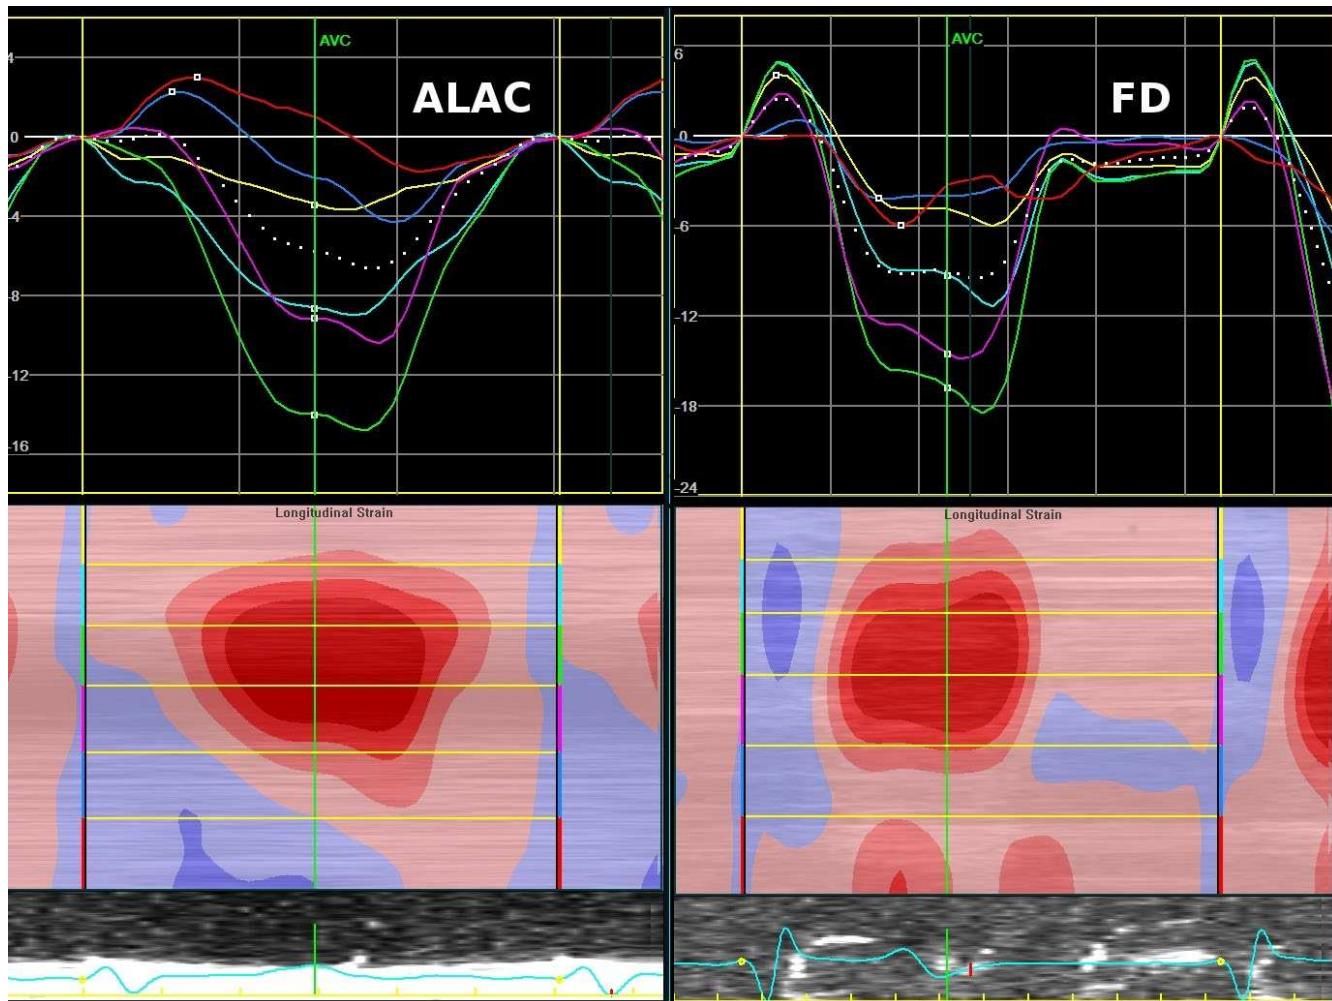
Examples of visually similar patterns of relative apical sparing of longitudinal strain in the A4C view in a patient with ALAC and FD, respectively (A4C = apical 4-chamber view; ALAC = AL amyloid cardiomyopathy; FD = Fabry disease-related cardiomyopathy)
